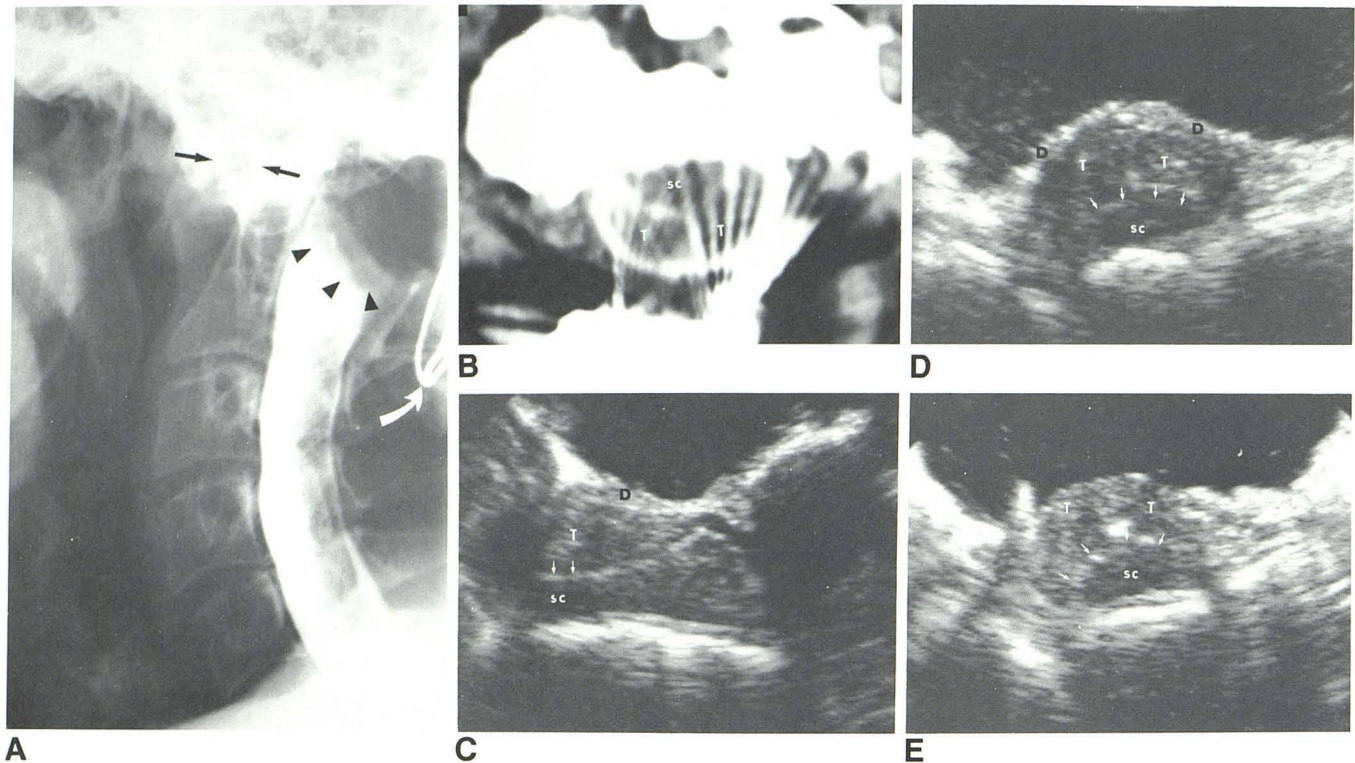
Posterior wire fusion was performed at another hospital for atlantoaxial subluxation in patient who was thought to have rheumatoid arthritis. Postoperatively, increased quadriparesis, dysphagia, urinary hesitancy, and nystagmus prompted reevaluation. A, Water-soluble-contrast myelography shows atlantoaxial subluxation (*black arrows*), lower half of posterior wire fusion (*curved arrow*), and mass (*arrowheads*) in spinal canal at C1. B, Contrast CT image is degraded because of streaking from wires; however an intradural mass diagnosed as cerebellar tonsils (T) is seen in posterior part of canal and displacing spinal cord (SC) anteriorly. Posterior fusion was removed, but despite
